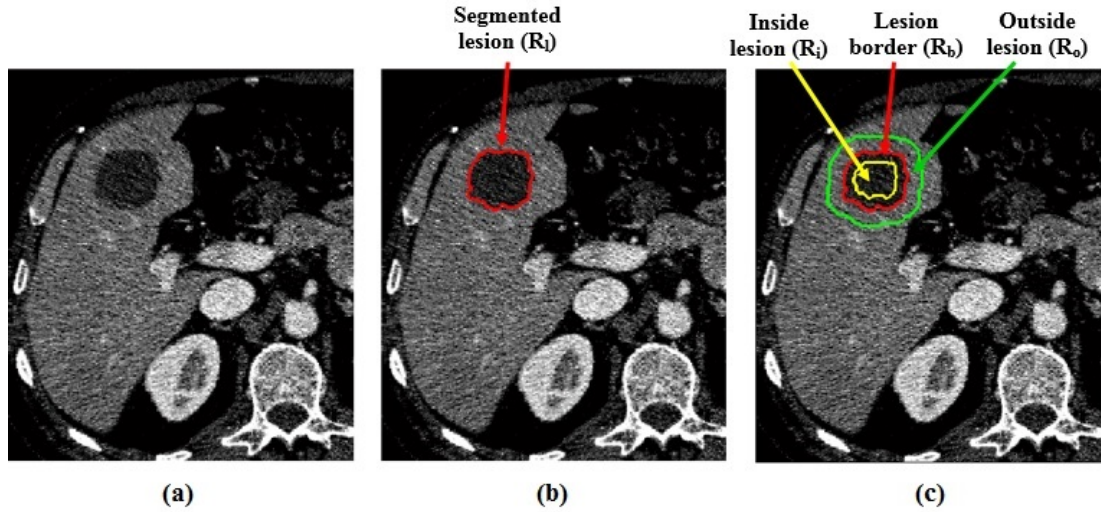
Proposed framework for multiple ROIs selection; (a) Original CT image; (b) The segmented lesion in red border; (c) Three defined ROIs which are outside lesion is green, lesion border is red and inside lesion is yellow.
